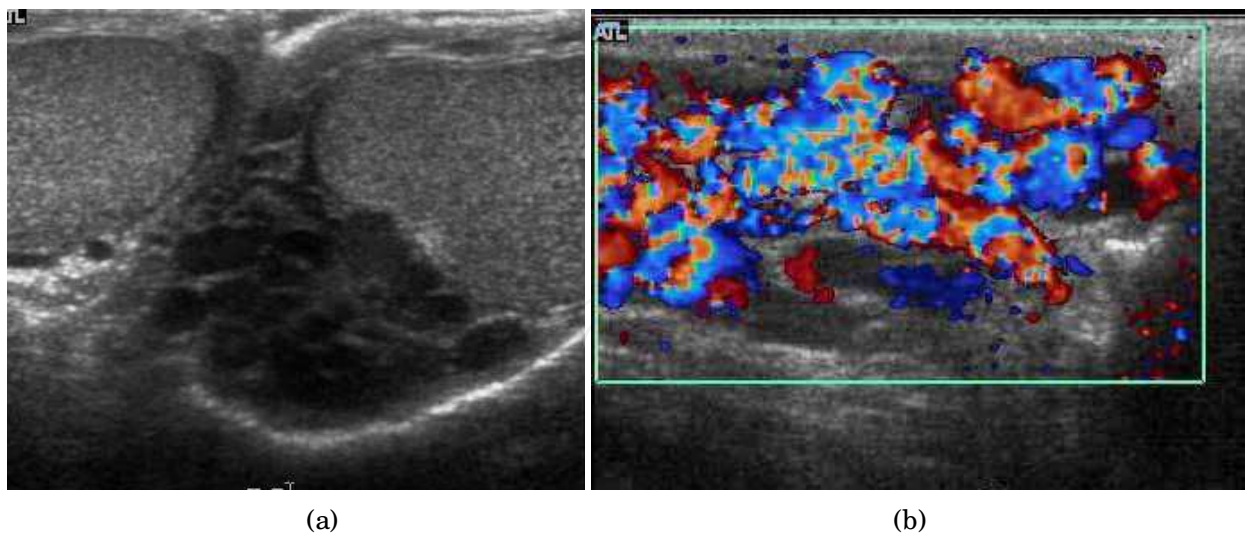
Varicocele. (a) Multiple tortuous tubular like structure are seen in the left scrotum. (b) Color Doppler sonography shows vascular reflux during Valsalva's maneuver
